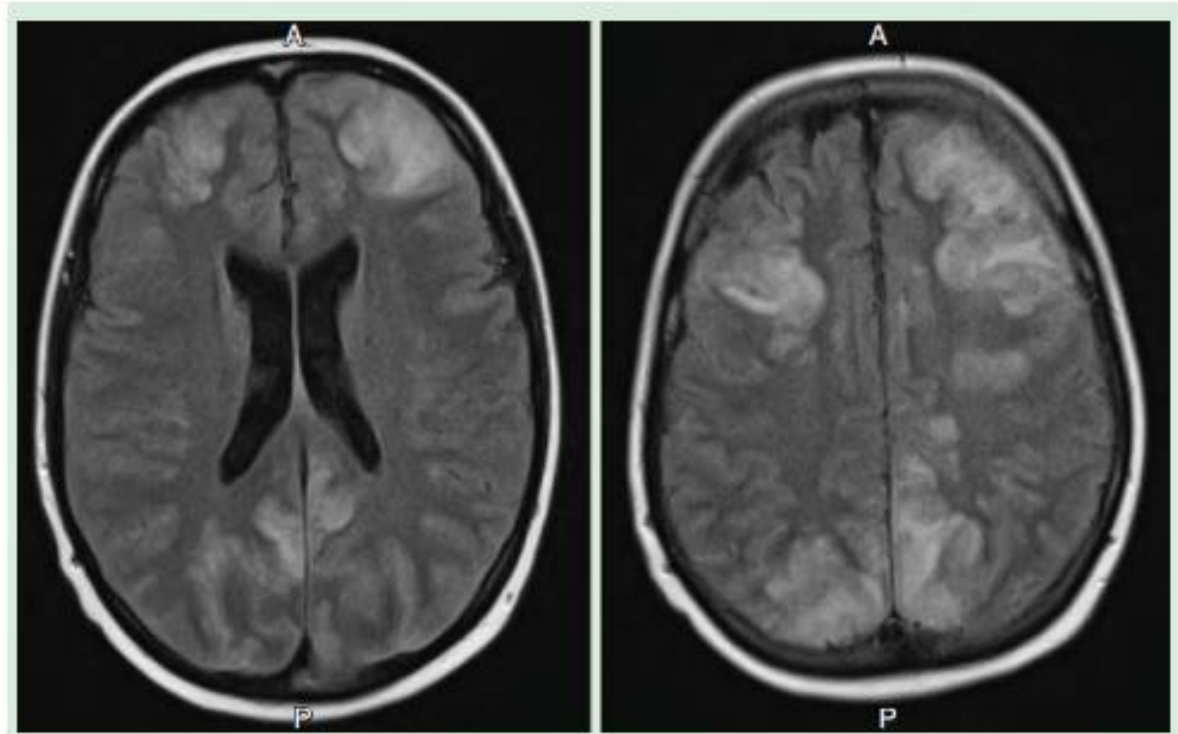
Posterior reversible encephalopathic syndrome seen in MRI fluid attenuated inversion recovery imaging of a patient treated with a cytarabine containing regimen involving both frontal and posterior lobes.
